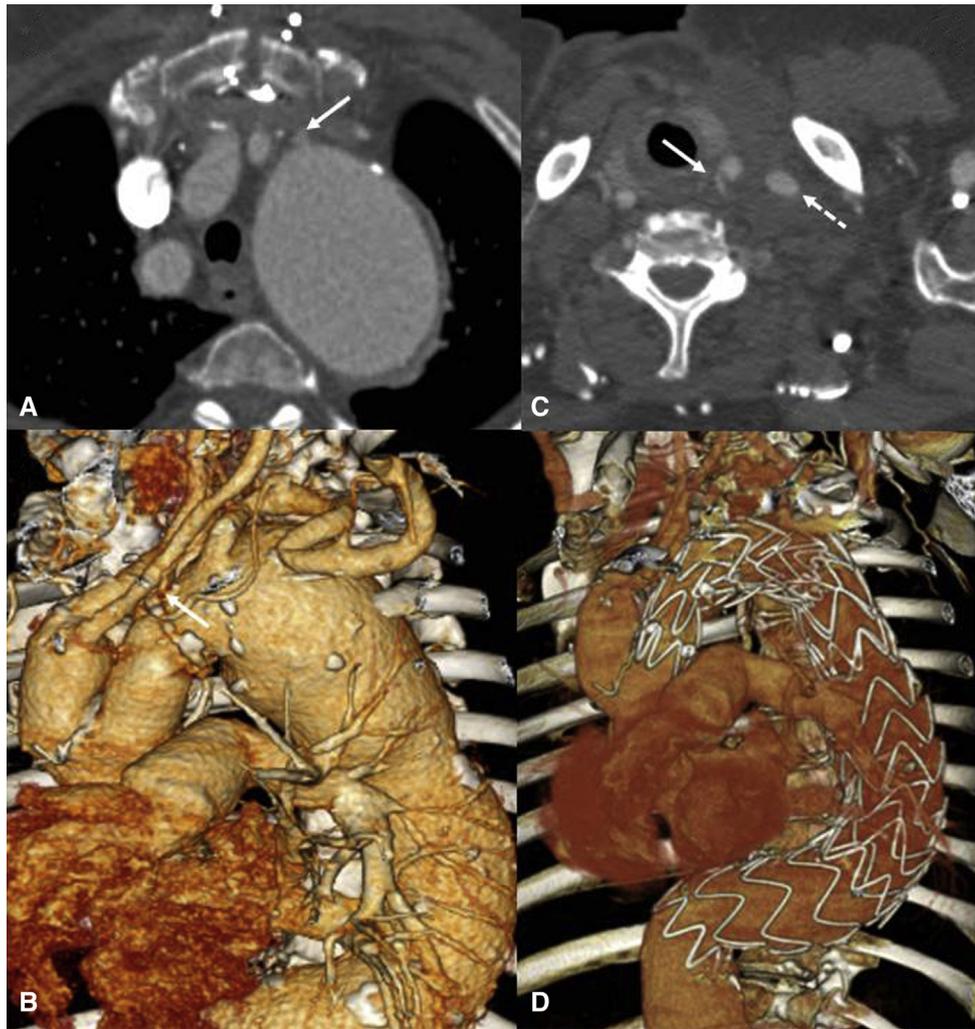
Hybrid type II arch repair: CTA (A) showed the origin of the ILVA directly from the arch aneurysm (A, *white arrow*). Postoperative volume rendering 3-dimensional reconstruction (B) showing the proximal anastomosis of the ascending/arch graft performed just proximally to the origin of the ILVA (B, *white arrow*). Follow-up CTA control documenting the patency of the transposed ILVA onto the LCCA (C, *white arrow*) and the prosthetic CSbp (C, *white dotted arrow*). Complete reconstruction of the ascending/arch/descending aorta (D) in a 2-stage approach.
